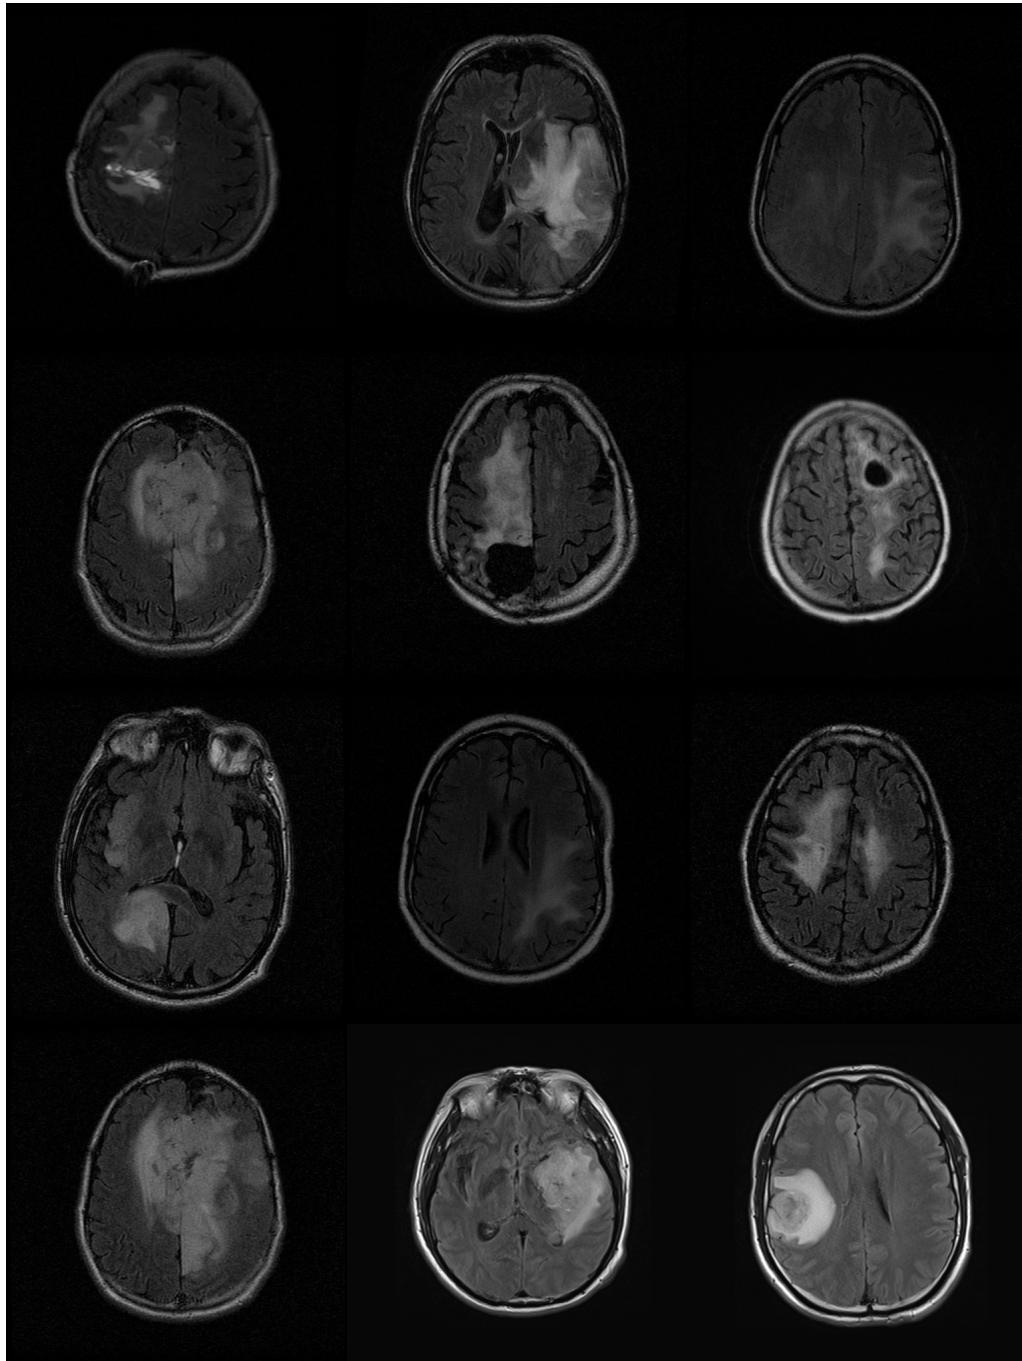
The MRI examples of Patient 2 to Patient 13.
